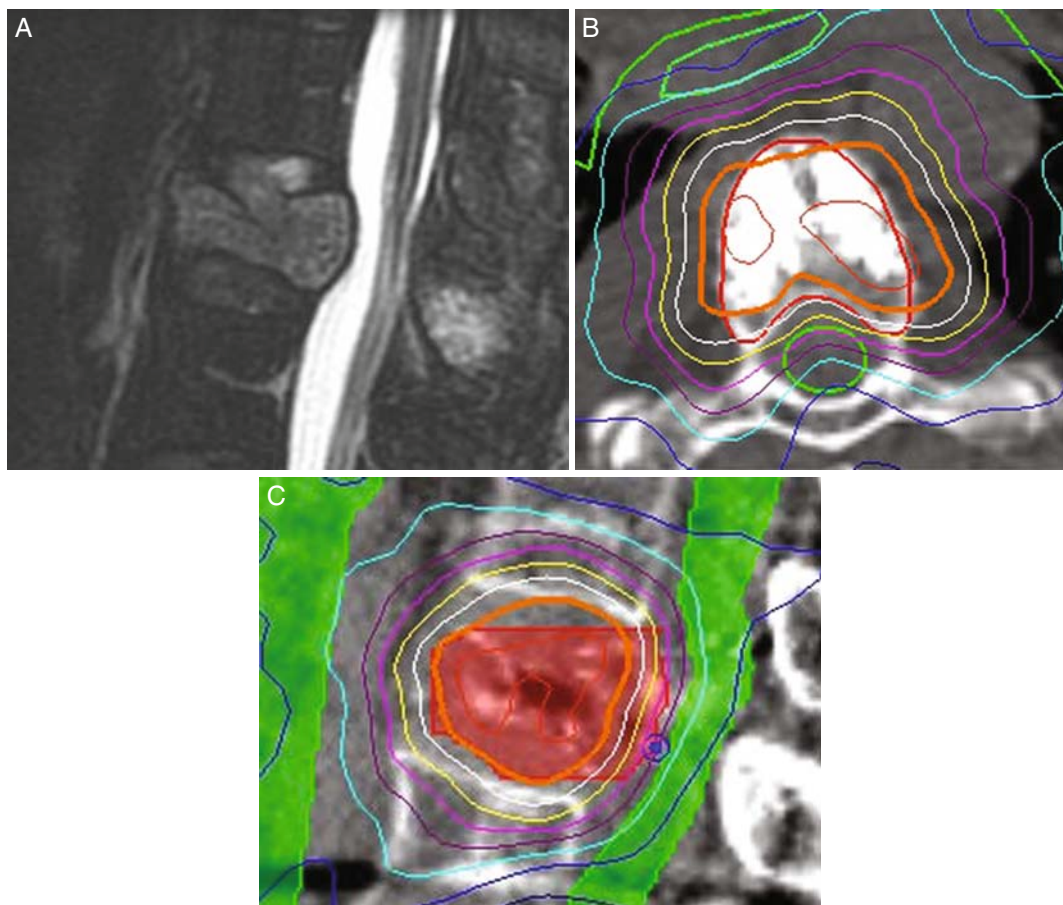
A case example of an L1 thyroid carcinoma metastasis in a 75-year-old man. The patient, treated previously with conventional external beam irradiation, presented with pain recurrence and radiography indicated his tumor had progressed. A T2 sagittal MRI shows a pathologic L1 compression fracture with spinal canal compromise (A). The patient underwent percutaneous transpedicular methylmethacrylate placement and biopsy. He subsequently received radiosurgery to the lesion with a maximum prescription dose of 22.5 Gy delivered in a single session. The maximum dose to the spinal cord was 8.5 Gy (B and C). (Courtesy of University of Pittsburgh Cancer Institute.)
